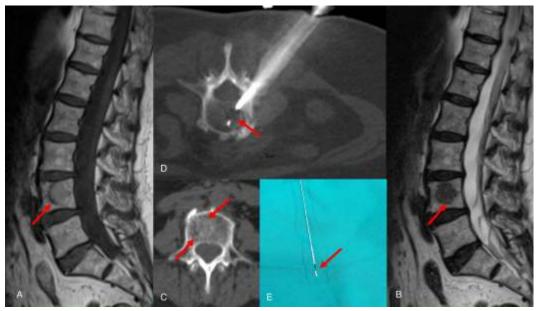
Metastasis from malignant melanoma. 72-years old lady with ocular melanoma had backache. T1W (A) and T2W (B) sagittal MRI images of the spine show a focal lesion in the L4 vertebral body with subtle sclerosis on the axial CT (C) image. The CT guided biopsy (D) was performed using a transpedicular route. The biopsy material (E) was black, confirming that this was melanin and hence consistent with metastasis from melanoma.
